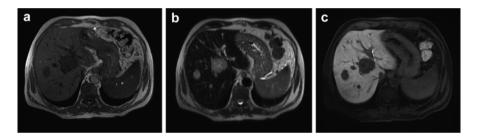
MRI scan: T1w (a), T2w, (b) and 3D liver acquisition volume acceleration (LAVA sequence) after hepatospecific contrast medium (c) show several PNET's liver metastases
